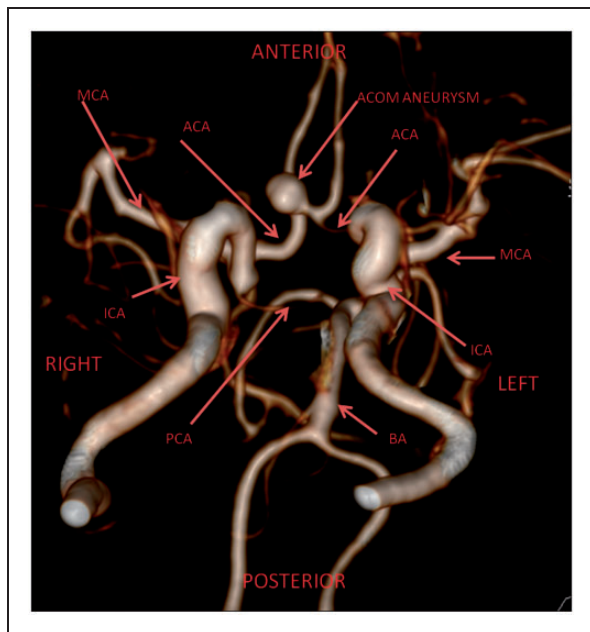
3D volume rendering computed tomography (CT) angiogram oblique image viewed from inferiorly looking superiorly showing anterior communicating artery (ACOM) aneurysm. The circle of Willis arteries are labeled as shown. MCA - middle cerebral artery, ACA - anterior cerebral artery, PCA - posterior cerebral artery, BA - basilar artery, ICA - internal carotid artery.
